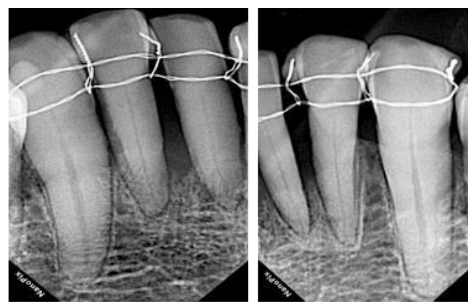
Follow up 3 months after surgery in case one; A. Intraoral clinical, B. Periapical radiographic
